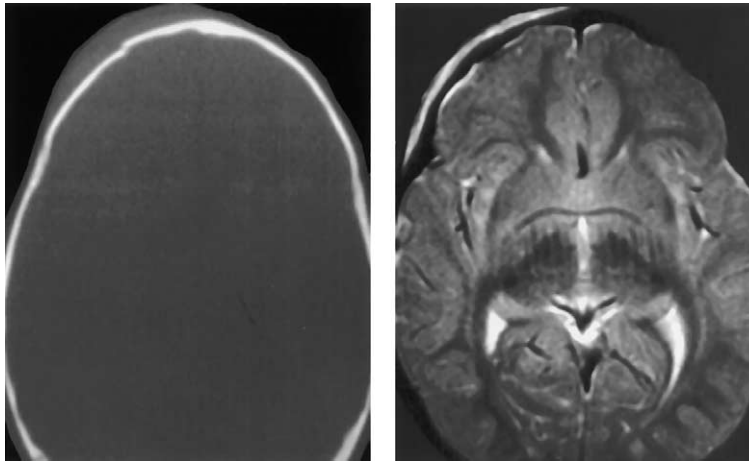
Axial CT scan in a young child with apparently mild head bump demonstrates soft tissue swelling and subtly displaced skull fracture (*left*). Axial T2-weighted image demonstrates small amount of subdural hemorrhage not seen on the CT scan, and the soft tissue hyperintensity of the scalp (*right*).
